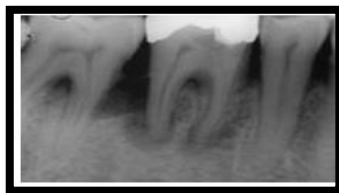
Mandibular first molar with a combined infection of true endodontic treatment and periodontal disease. This x-ray image shows endodontic and periodontal disease separately. The teeth were left untreated and the two lesions eventually merged.
